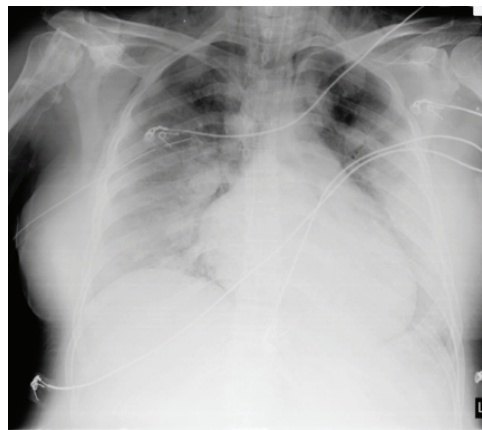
Chest x-ray after thoracic drain placement.
